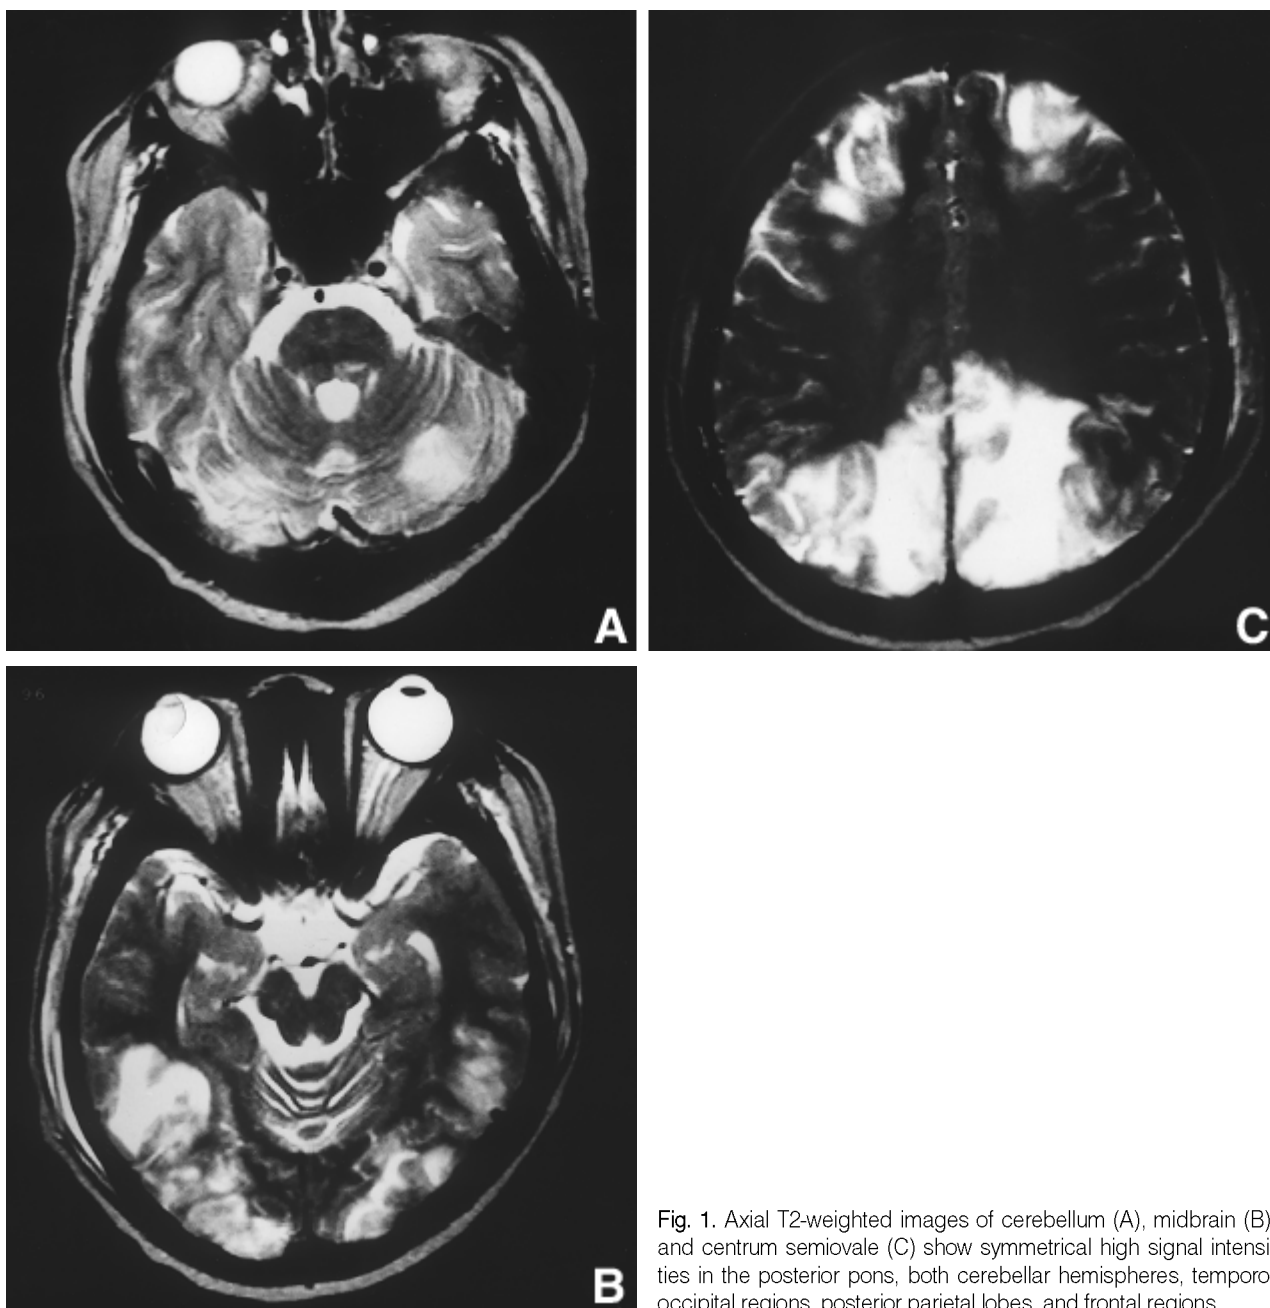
Axial T2-weighted images of cerebellum (A), midbrain (B), and centrum semiovale (C) show symmetrical high signal intensities in the posterior pons, both cerebellar hemispheres, temporo-occipital regions, posterior parietal lobes, and frontal regions.
